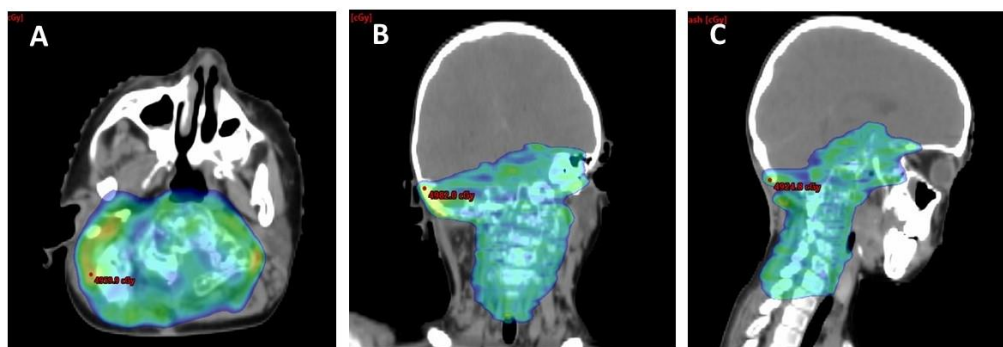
Radiation therapy planning. This figure shows three examples of CT scan axial (A), coronal (B) and sagittal images (C) used for radiation therapy treatment. The dose distribution is shown in wash color on the target volume in the three images.
